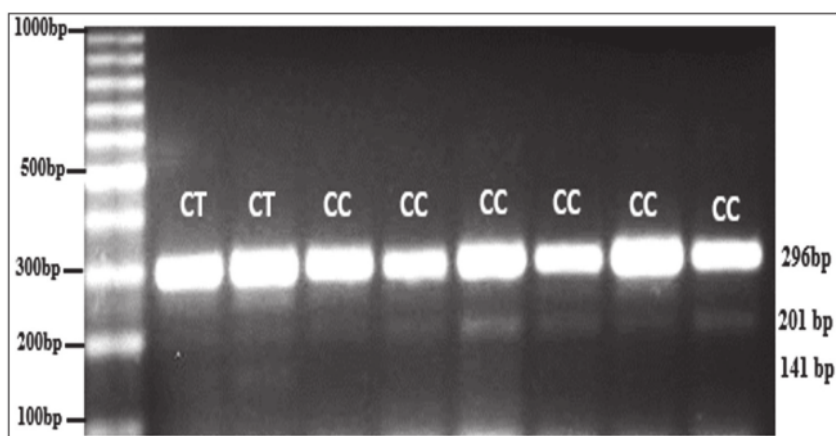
Visualization of DNA amplicon (healthy subjects) with CT and CC genotypes in the CTLA-4 gene rs5742909
